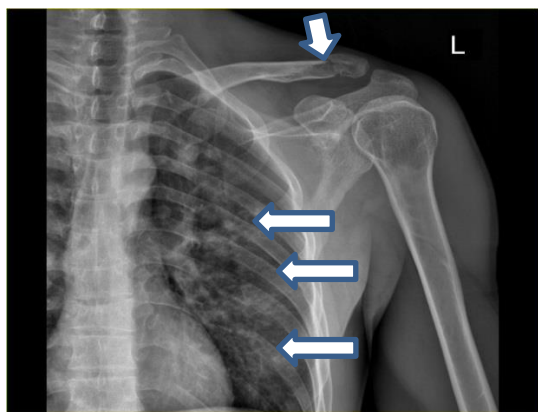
Case No. 2: long arrows showing peripheral opacities of both lungs, short arrow showing a distal clavicular fracture on the chest x-ray (CXR)
